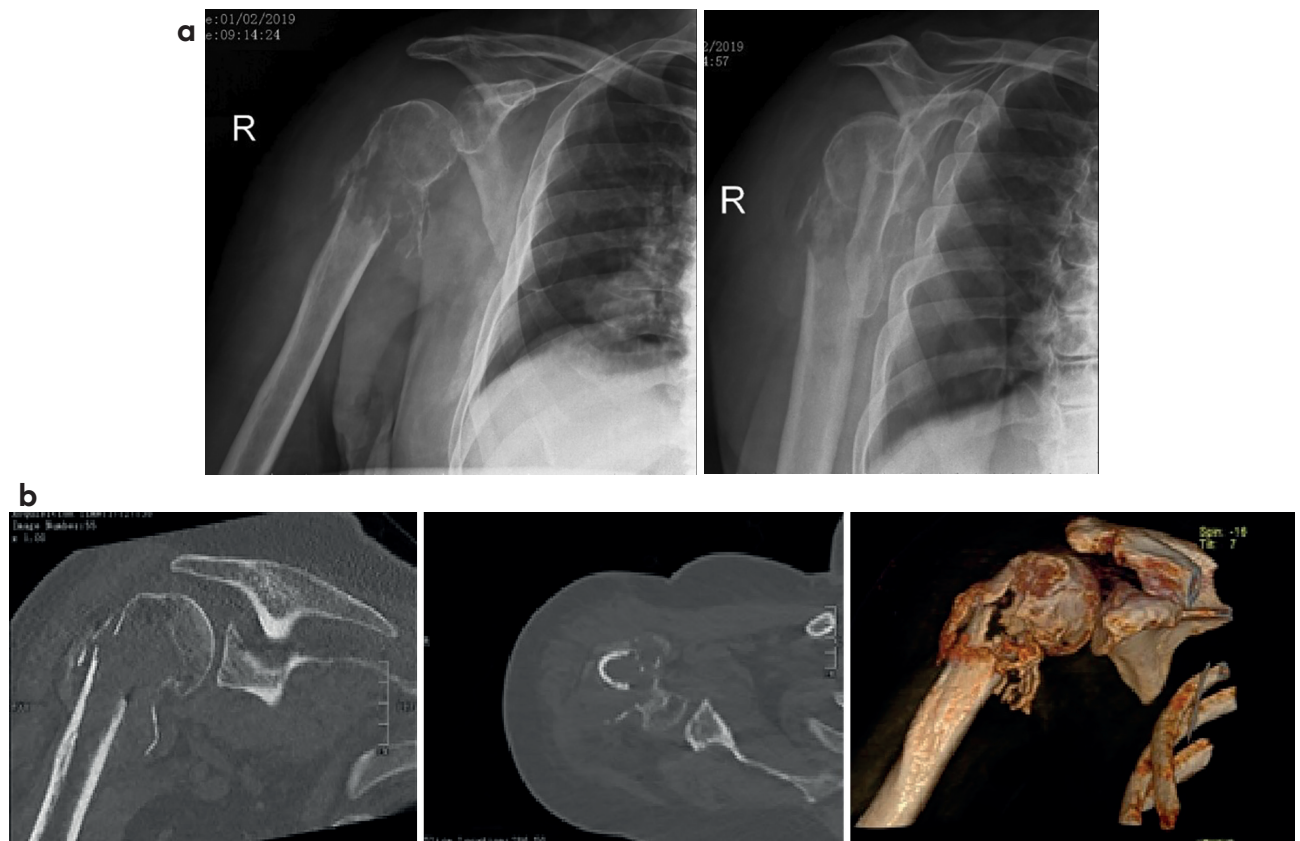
a) X-ray – multifragmentary fracture of the proximal third of the humerus, bone deformity and peri-osseous and metaphyseal expansion of the formation. b) CT – osteolytic tumor formation, engaging the humeral head, metaphysis and the upper third of the diaphysis. Formation size – 8 cm.
